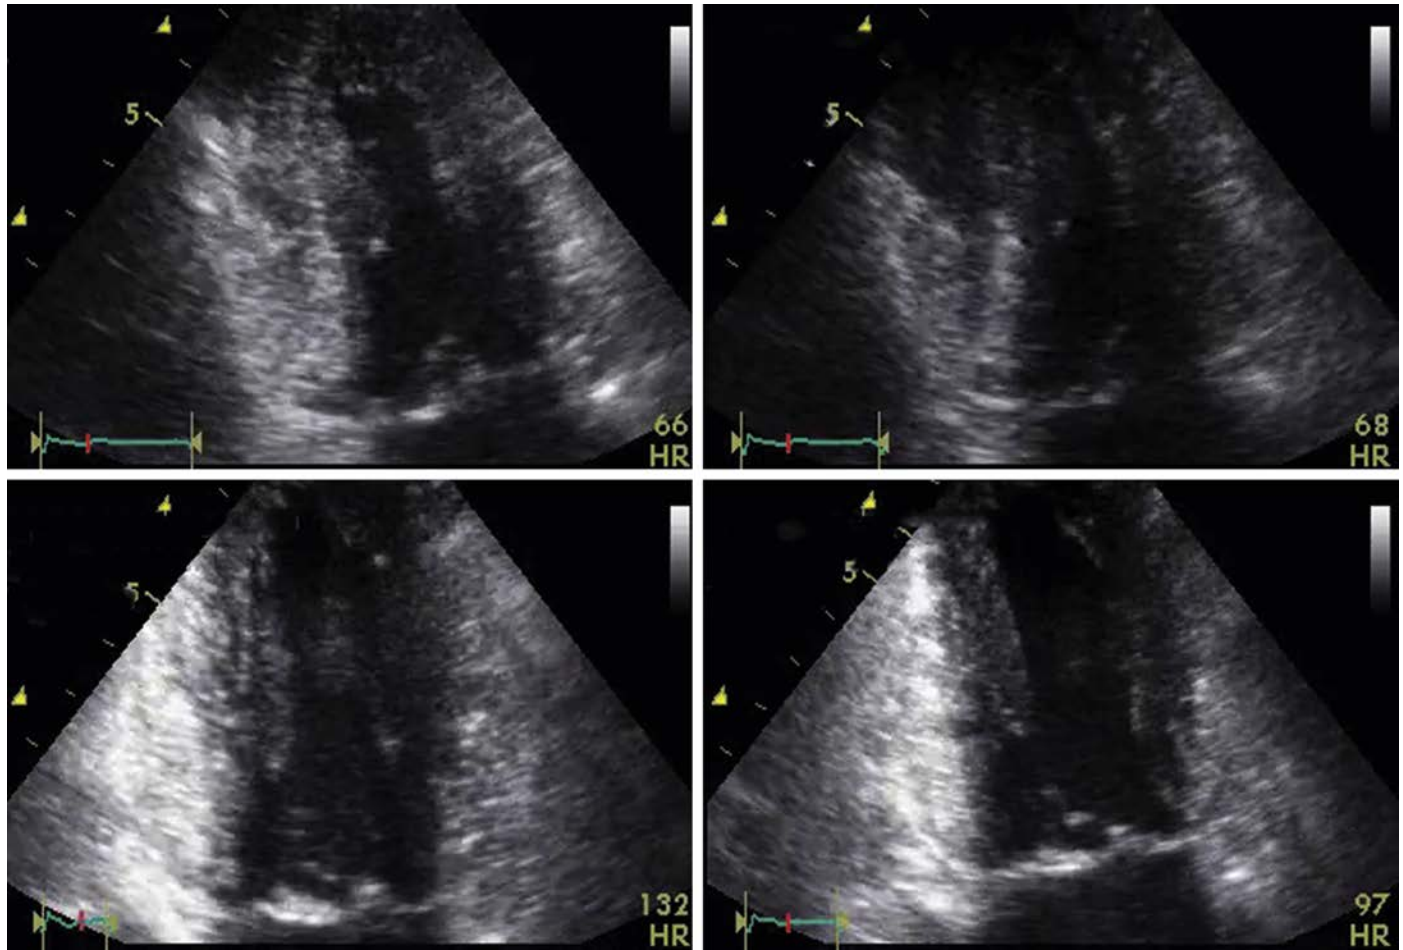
Dobutamine stress echocardiography (DSE). Upper left panel, DSE in apical two-chamber view demonstrating three-vessel disease. A biphasic response is shown, with improvement of contraction in the inferior and anterior walls at low dose of dobutamine ($10 \mu\text{g}/\text{kg}/\text{min}$, right upper panel), akinesia of the inferior and anterior walls with dyskinesia of the apex at higher dose ($40 \mu\text{g}/\text{kg}/\text{min}$, left lower panel), showing myocardial viability and ischemia, respectively. These changes persisted during recovery (right lower panel). (Courtesy of Dr. François Marcotte, Montreal Heart Institute.)
